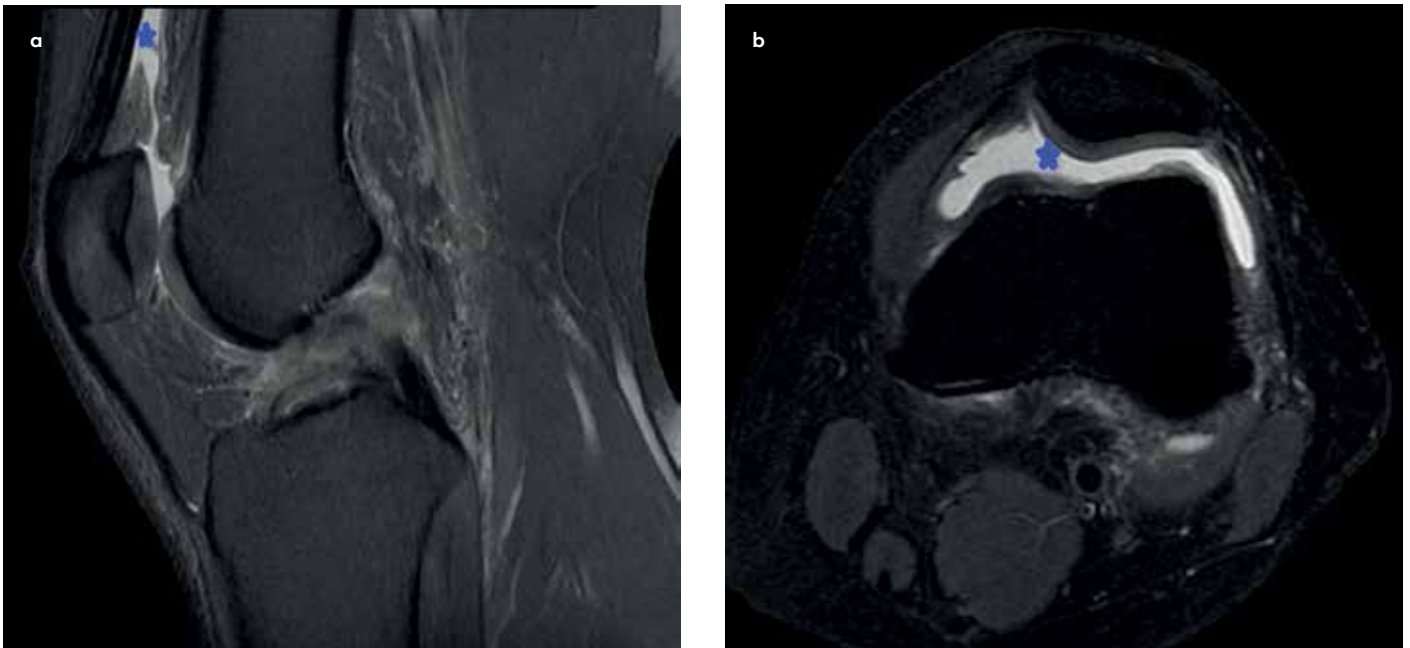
a-b. Sagittal proton-density MRI image of the knee: The asterisk marks the hemarthrosis. (a) Axial proton-density MRI image of the knee: The asterisk marks the hemarthrosis (b).
